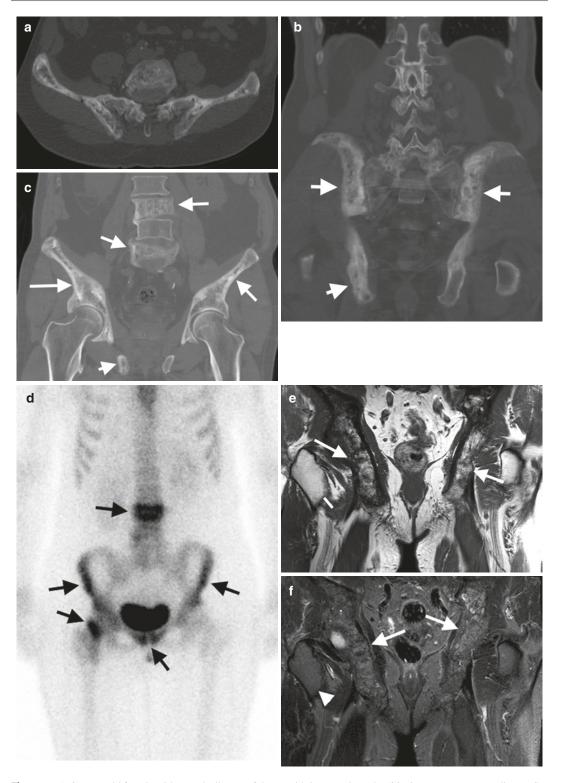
A 67-year-old female with Paget's disease of the pelvis, (a) axial CT superior pelvis with diffuse mixed sclerotic and lucent bone, (b, c) coronal reformat with multiple areas involved (*arrows*), (d) bone scan of the same patient
